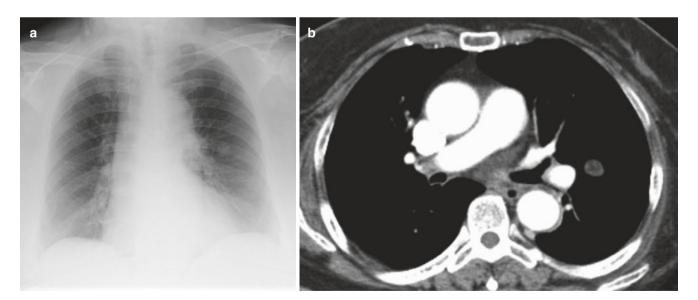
Nodule. (a) Frontal radiograph shows a nodule in the left mid-zone. (b) Axial CT image shows fat in the nodule consistent with hamartoma
